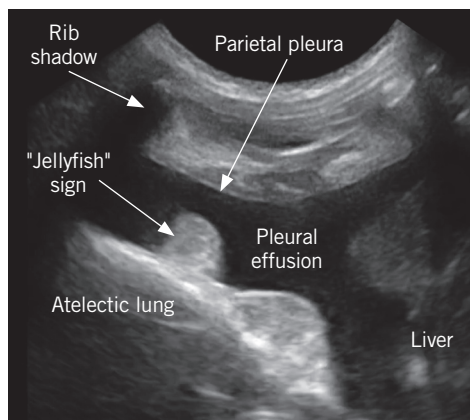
Image of an atelectatic lung (“jellyfish” sign) just dorsal to the pericardiophrenic (PD) window at the thoracoabdominal interface, transducer in perpendicular orientation to the ribs. When air is removed from lung, it adopts a tissue-like-pattern on ultrasound, meaning it becomes visible because ultrasound beams can now be transmitted through it (see Chapter 7, lung consolidation). Sometimes the atelectatic lung will move back and forth and have the appearance of a “jellyfish”.
